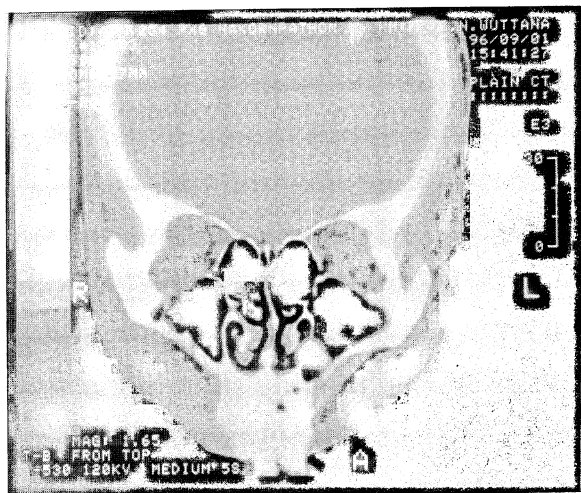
A coronal CT scan showing the opaque mass attached to the medial wall of left maxillary sinus.
